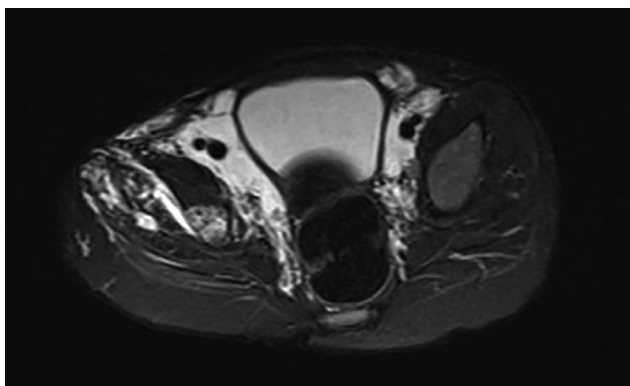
Three-year-old boy with CCLA. Axial T2 fat-saturated MRI sequence. Perivascular high-signal soft tissue is seen in the pelvis, with infiltration of the surrounding muscles and soft tissue on the right.
